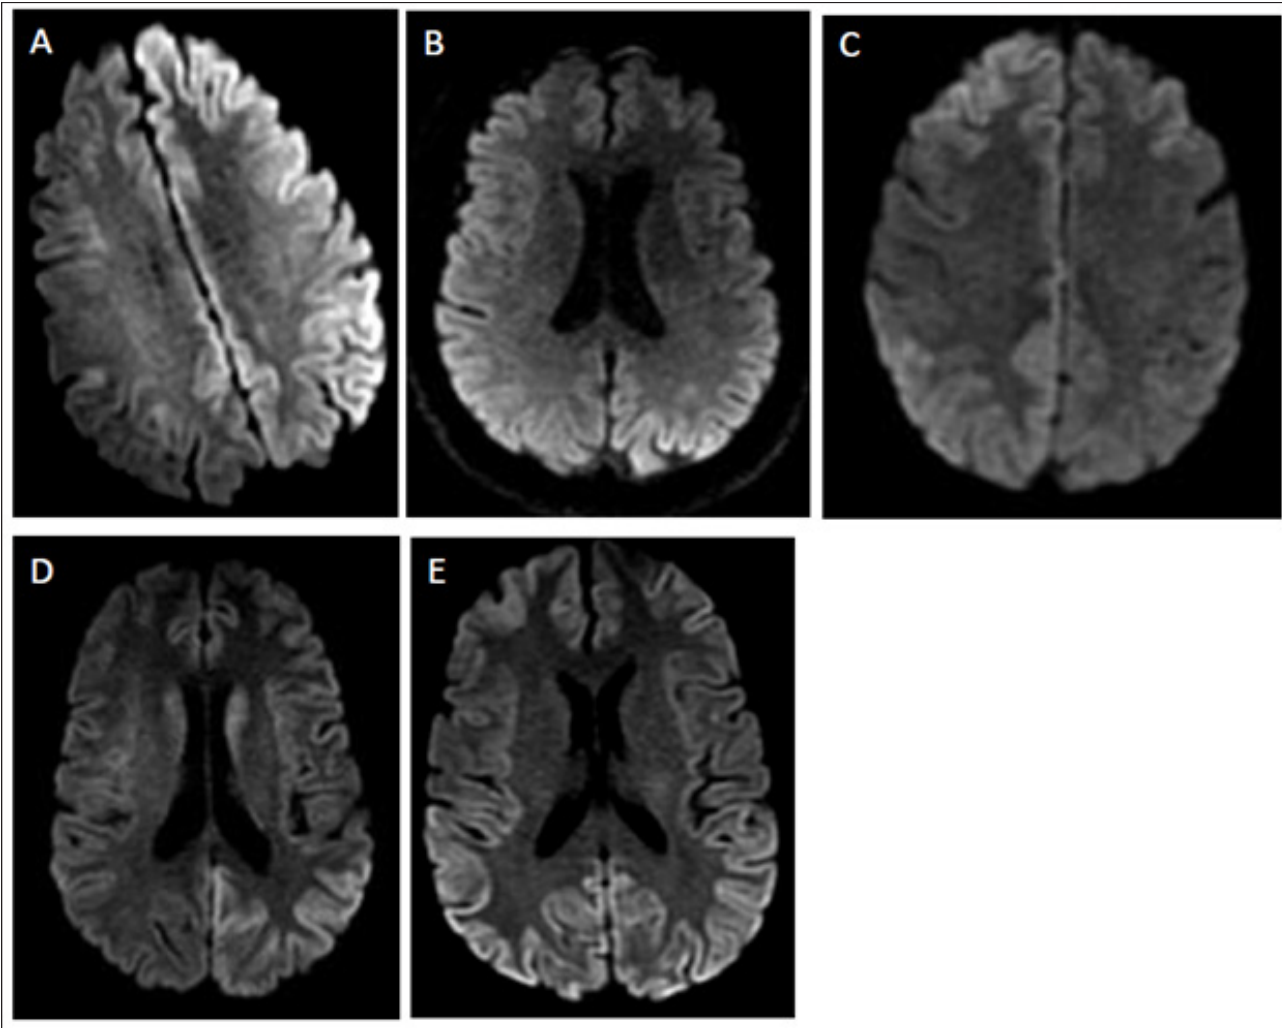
Examples of cortical ribboning in diffusion-weighted MRI brain.
